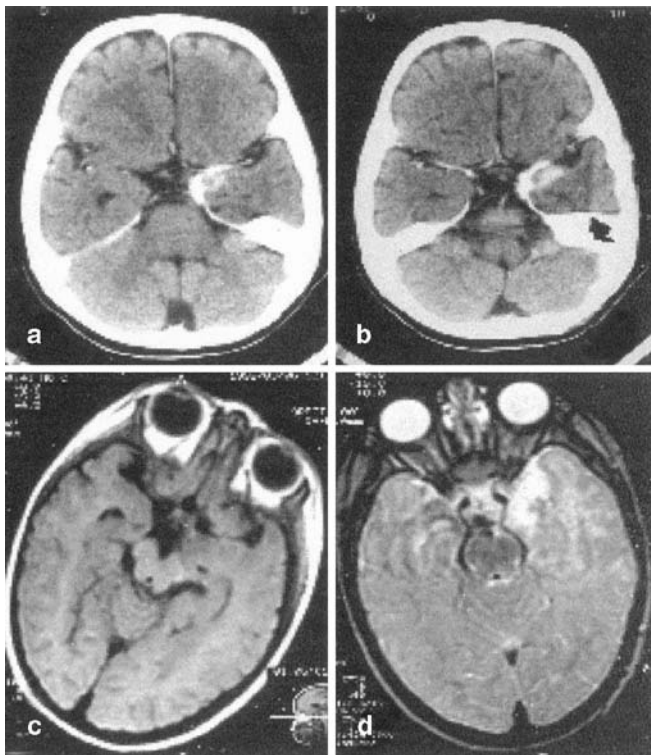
a CT scan. An enhancing lesion in the temporal lobe medial and anterior to the uncus, located superficially along the meninges. b Contrast-enhanced CT. Focal intraparenchymal enhancing lesion seen in the temporal lobe, in addition to the meningeal lesion. c T1-weighted MRI. The lesion is isointense to the brain. d T2-weighted MRI. The lesion is hyperintense without any differentiation of the extraparenchymal lesion from the intraparenchymal pathology.
